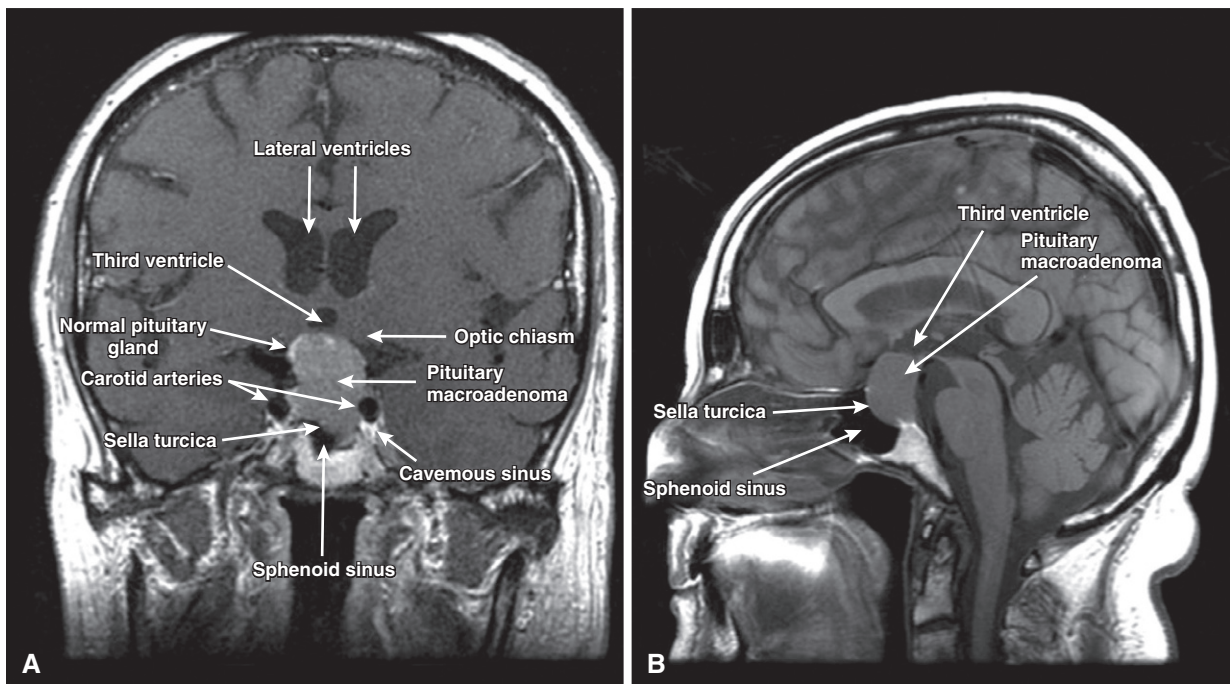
Magnetic resonance images demonstrating a large pituitary adenoma and the anatomy adjacent to the sella turcica. A, Coronal plane. Residual normal pituitary tissue is demonstrated being pushed laterally and superiorly by the enlarging pituitary mass. Superiorly, the mass is compressing the optic chiasm, a small portion of which is visible. A thin layer of the bone of the sella turcica can be seen on the inferior border of the mass, with a portion of the sphenoid sinus visible immediately inferior to it. Because of the bony inferior border, the tumor has grown superiorly with resultant compression of the optic chiasm. B, Sagittal plane. The third ventricle is superior to the macroadenoma and the prepontine/interpeduncular cistern lies posteriorly. This cistern contains portions of the circle of Willis and its branches. Violation of this cistern can result in significant vascular and neurologic injury. The route to the mass through the nasal cavity and the sphenoid sinus is demonstrated on this image by the trajectory of the arrow through the sphenoid sinus.
